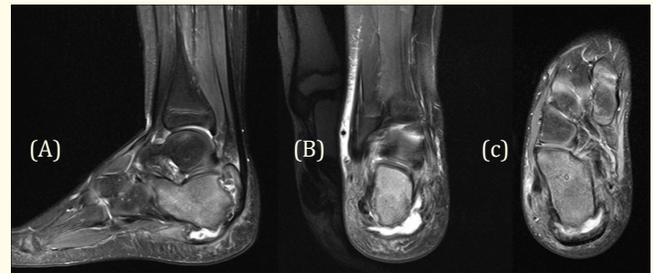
T2-weighted lateral (A), anteroposterior (B) and axial (C) MRI images of the right foot demonstrating an unusual destructive process centred on the calcaneal growth plate and adjacent apophysis.
